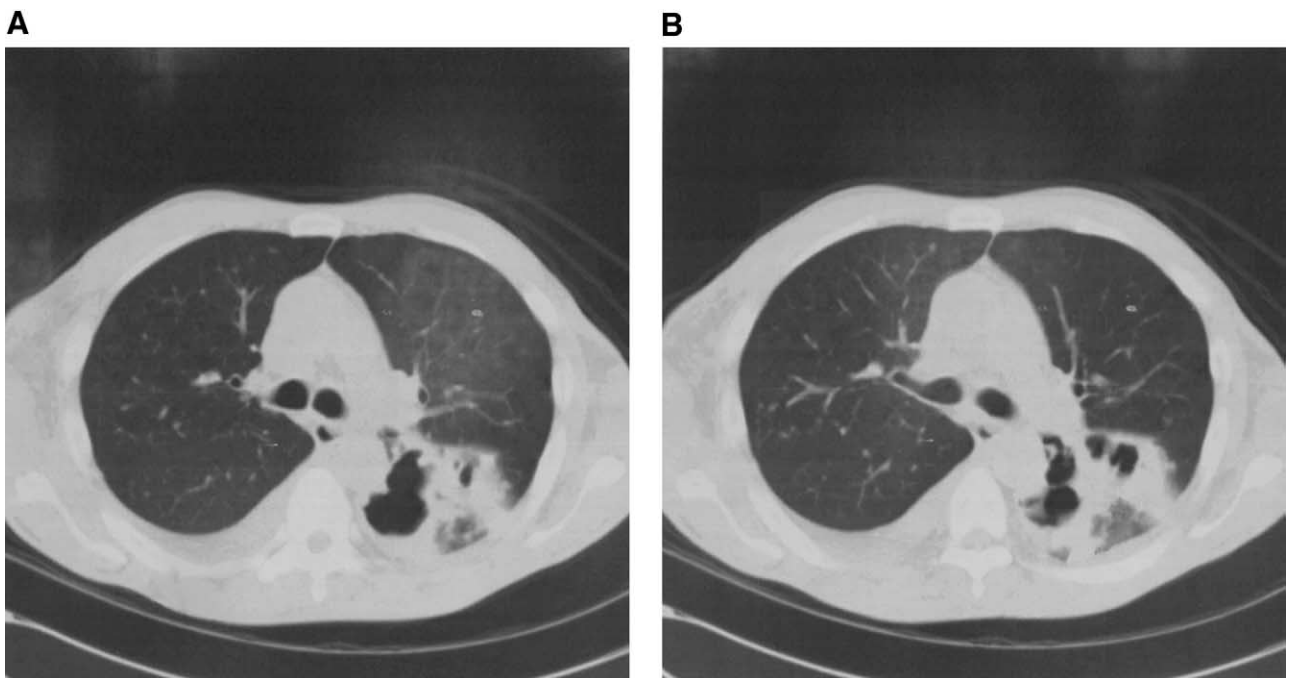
CT chest showing large multilocular cavitary lesion.
